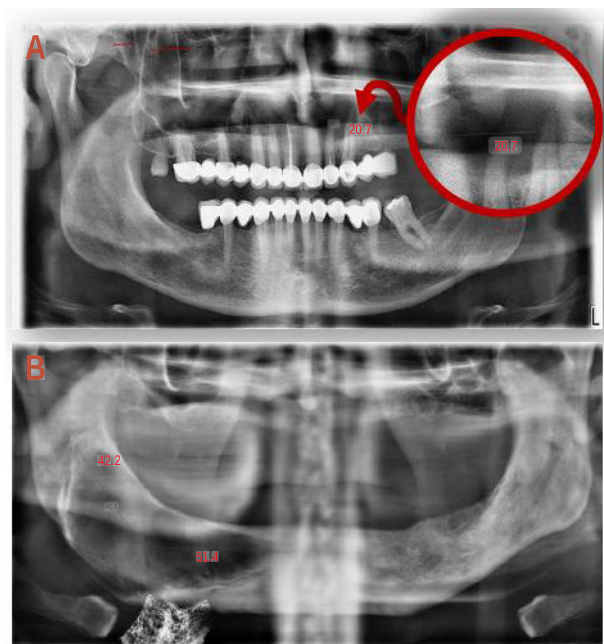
A: Radiographic view of a radicular cyst with the smallest measured dimension in the study of 21 mm. B: Radiographic view of a residual cyst with the largest measured dimension in the study of 94 mm.
